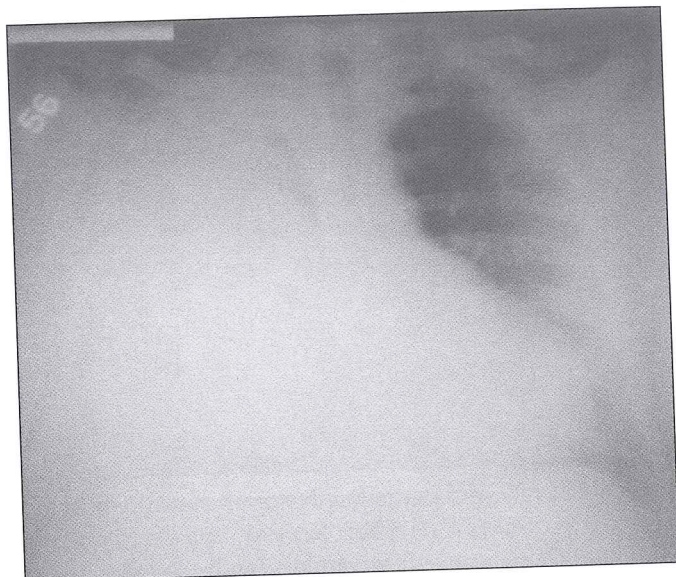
Radiographic appearance of the chest
